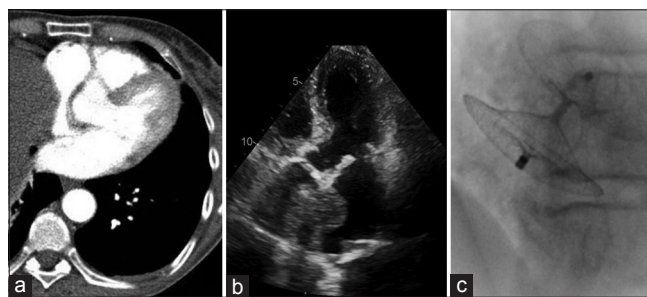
Computerized tomography scan demonstrated an ab-estrinsec compression of the right atrial roof due to peritoneal carcinomatosis and subsequent elevation of the right hemidiaphragm (a), A microbubble contrast-enhanced echocardiogram showed bubbles within the right to the left atrium (b) and endovascular closure of the atrial septal defect was successfully performed (c)
